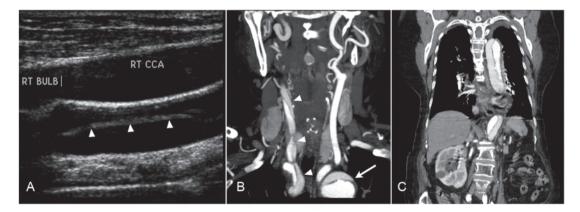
(A) Extra-cranial carotid duplex in longitudinal section showing a dissecting intima flap (arrowheads) in the right common carotid artery (CCA). (B) Neck CT angiography in the coronal plane demonstrating true and false lumens in the right CCA (arrowheads) and the aortic arch (arrow). (C) Chest and abdominal CT in the coronal plane showing involvement of the descending aorta.
